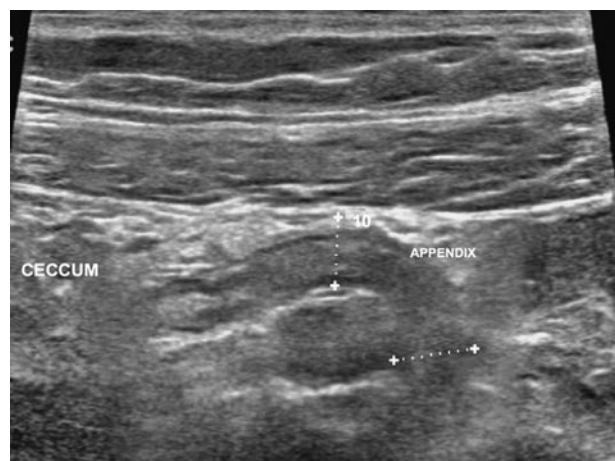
Transverse ultrasound of the right lower quadrant with a non-compressible 10-mm tubular structure compatible with appendicitis.
